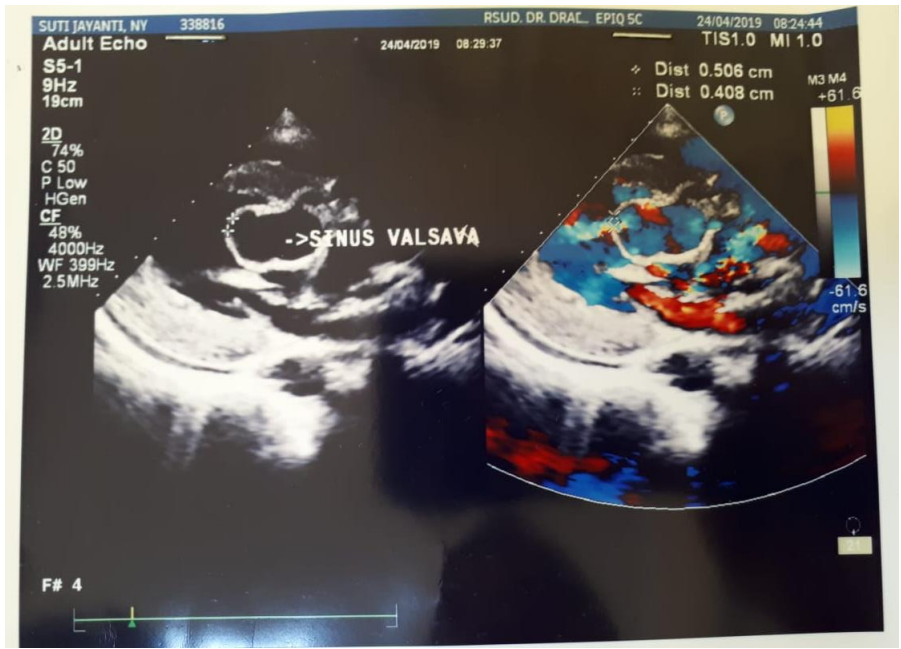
Transthoracic echocardiogram in apical 3-chamber view shows the ruptured sinus of Valsava (arrow) and TTE with color-flow Doppler (right)
